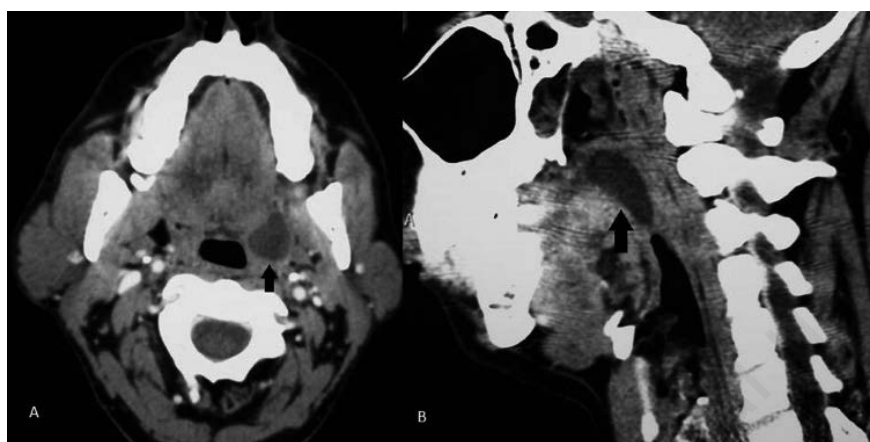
Computed tomography scan neck with contrast enhancement showing well delineated abscess in the left tonsil in axial (A) and coronal cuts (B).
